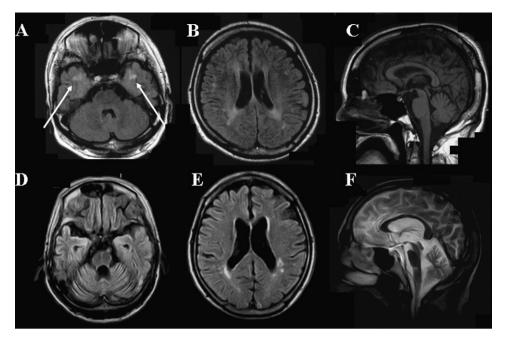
Brain MRI studies of cases 1 and 2. (A–C) FLAIR MRI of case 1; (D–F) FLAIR (D and E) and T2-weighted MRI (F) of case 2. Note FLAIR/T2-high lesions in the subcortical white matter of the temporal tip (A, arrows), periventricular FLAIR/T2-high lesions (B), mild cerebellar atrophy in the anterior lobe (C), no lesions in the white matter of temporal tip (D), mild periventricular FLAIR/T2-high lesions (E), and marked atrophy of the cerebellum and brainstem (F).
